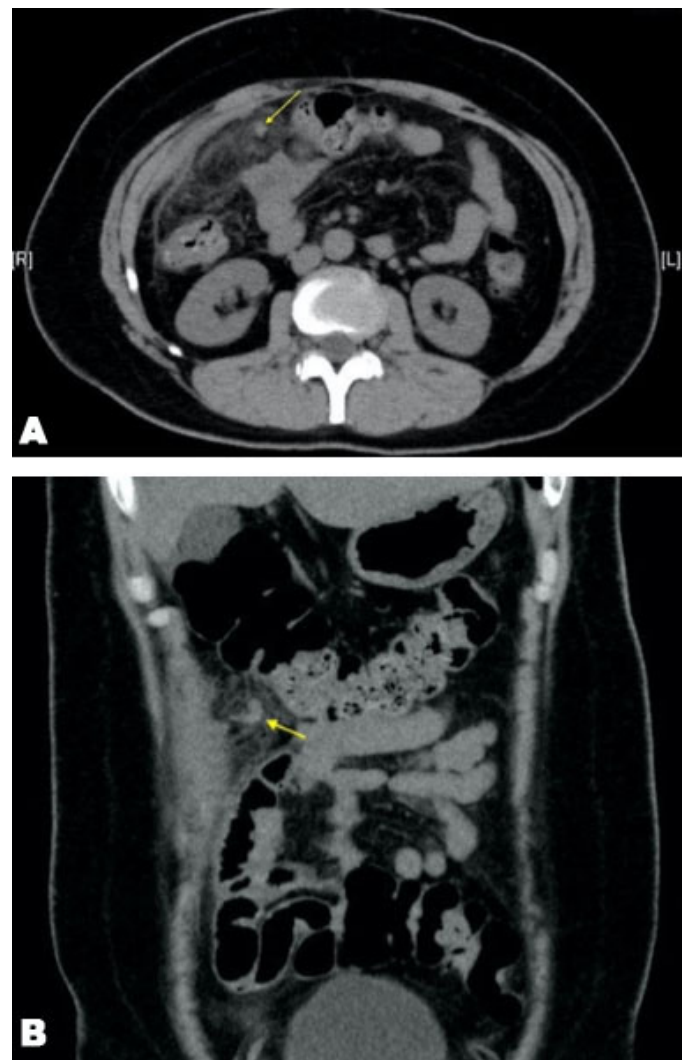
(A and B): Coronal and axial CT images showing typical whirl sign. A twisted blood vessel in the greater omentum is indicated by arrows. Hyperdense area around the whirl sign implies necrotic fat tissue in the greater omentum.
